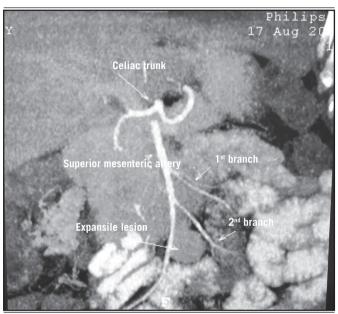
CT: expansile lesion in the mesentery CT: computed tomography.
